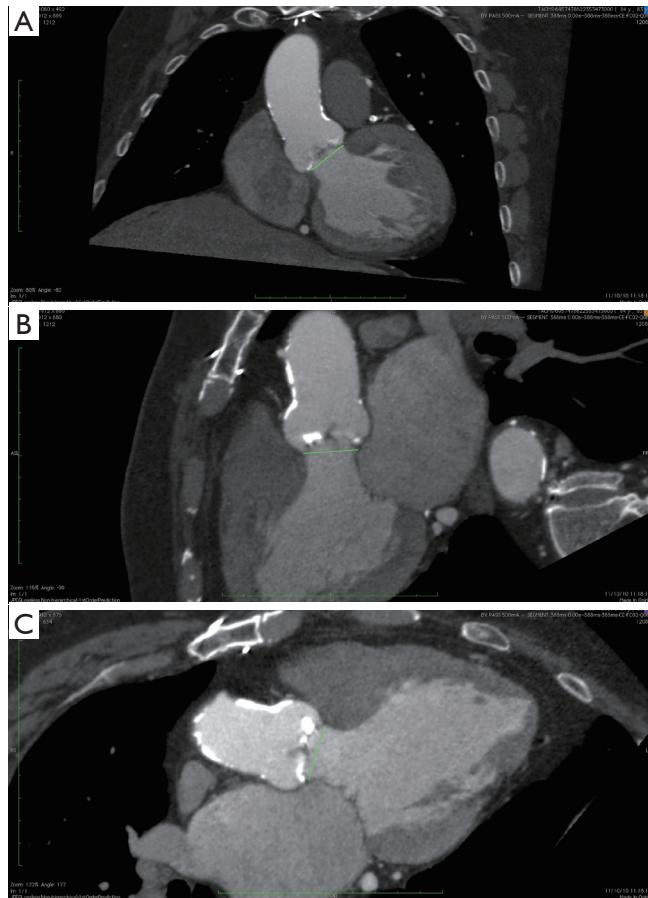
“Hinge-to-hinge” measurements of the aortic annulus diameter may be performed on coronal oblique (A) and sagittal oblique (B) reconstructions, or in the so-called “3-chamber reconstruction”, that replicates the long axis echocardiographic images. This view may be easily obtained by generating a short axis view at the base of the left ventricle, diagonal to the line traced from the center of the mitral valve to the left ventricular apex, and then placing a cut-plane at the base of the short axis projection out to left ventricular outflow tract and aorta (C)
